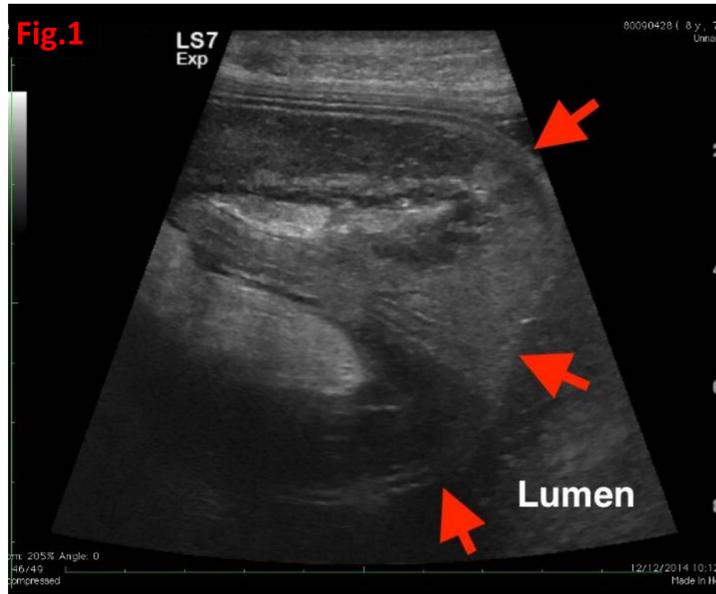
Ultrasonographic image from a transverse ventral abdominal approach. The inverted pylorus (intussusceptum, red arrows) is identified projecting into the stomach lumen. The wall of the intussusceptum is markedly thickened.
